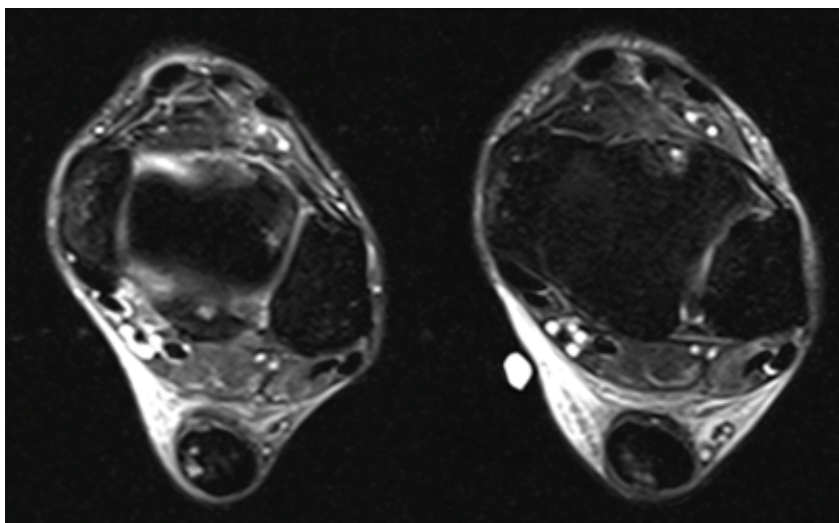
Axial MRI showing longitudinal peripheral interstitial tear of the mid-tendon (A) that recovered 33 days after CLARIX® FLO treatment.
